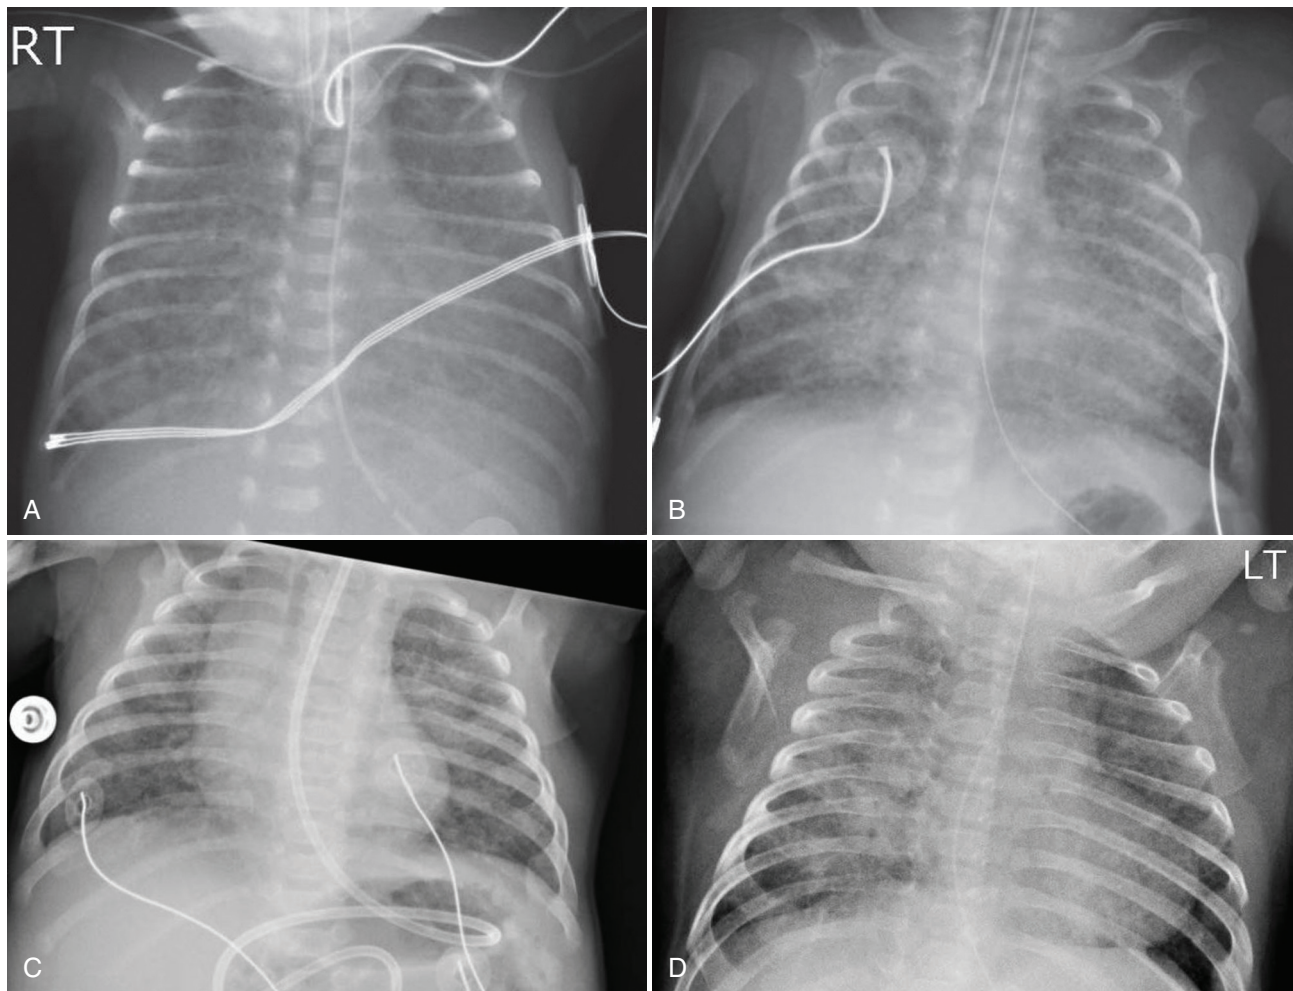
These images are from the same patient as Figure 22-1, an infant born at 27 weeks of gestation with respiratory distress syndrome. They represent progression of lung disease into “new” bronchopulmonary dysplasia over time. These images differ from “old” BPD, in which radiographs showed developing cystic changes and hyperinflation. The images are taken at (A) 2 weeks of age, with developing coarseness to lung disease (also note endotracheal tube in upper trachea); (B) 1 month of age, with increasing heterogeneity and differential areas of atelectasis and edema (again, patient remains intubated); (C) 3 months of age, with coarseness and low lung volumes (also note post pyloric feeding tube, which is partially visualized); and (D) 5 months of age, with edema and some small cystic changes noted.
